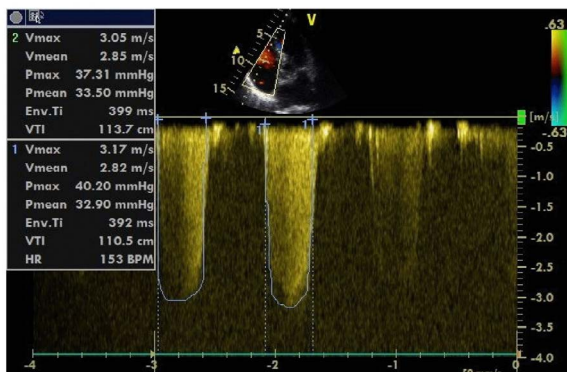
Echocardiographic assessment of transtricuspid pressure gradients to calculate PASP
